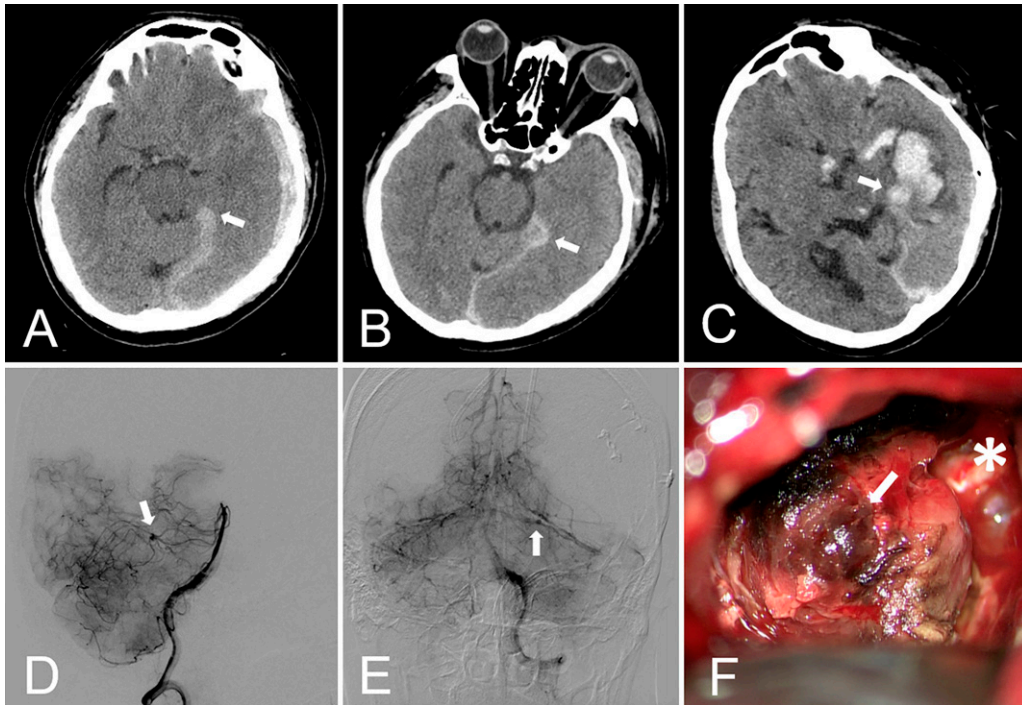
Diagnostic assessments of the case. Cerebral CT showed progressive SDH at (A) 10 days after the fall and (B) 2 days and (C) 9 days after the first craniotomy. The aneurysm presented as a hyperdense lesion adjacent to the tentorial edge (arrows). D and E: Cerebral angiography showed an aneurysm with delayed contrast filling and emptying (arrow) at the left distal SCA. F: Intraoperative finding of the aneurysm (arrow) adjacent to tentorial edge (asterisk).
